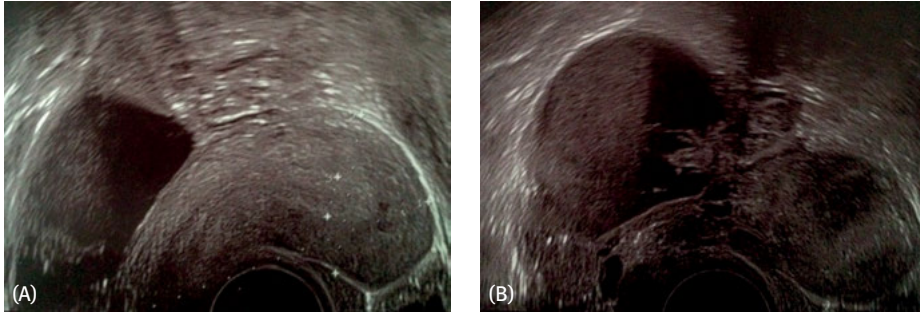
Endometriosis-associated extrauterine peritoneal adenosarcoma. (A) sagittal vaginal sonography reveals a cystic tumor that is clearly localized in the Douglas pouch. The weak echoes in the cystic component of the tumor correspond to hemorrhages so identified intraoperatively. The small tumor in the uterus turned out to be leiomyoma; (B) transverse sonography shows that the tumor consists of solid and cystic or necrotic components. The hemorrhages are also clearly visible. A deep concretion with the serosa of the uterus was confirmed during surgery.
